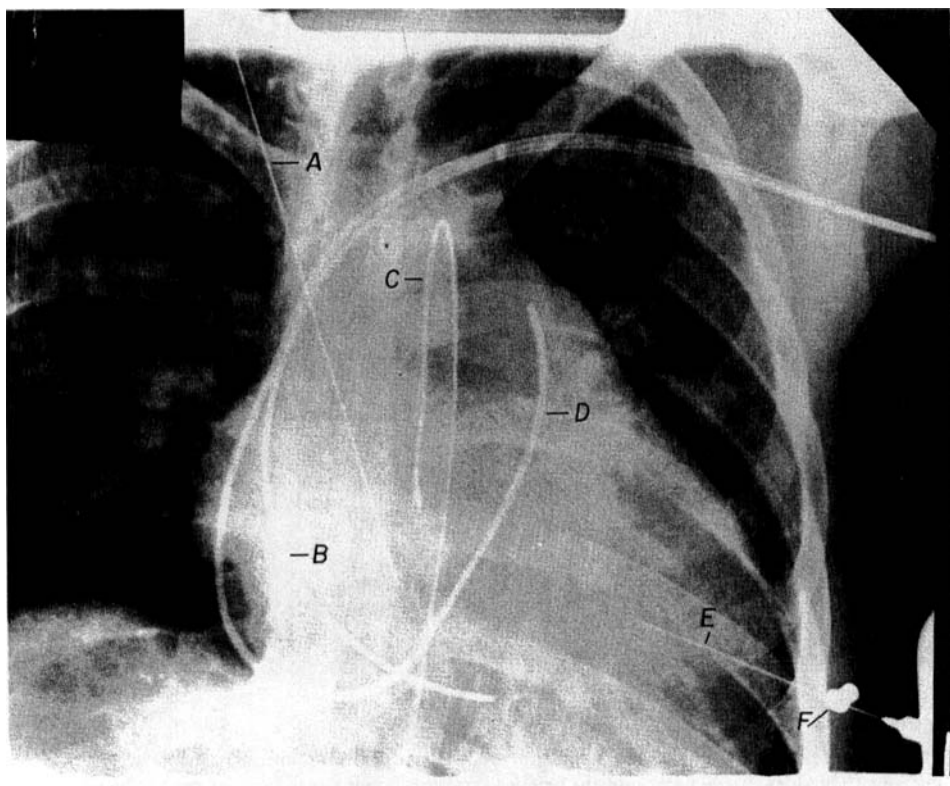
Roentgenogram of the thorax of a 40-year-old man demonstrating the positions of needles and catheters during combined puncture of the left atrium and the left ventricle and catheterization of the aorta and the right side of the heart. (A) 21T-gauge needle, 23 cm long, outside diameter 0.8 mm, internal diameter 0.6 mm, has been inserted via the suprasternal route, and its tip has been advanced until it lies in the left atrium, (B) no. 6-F cardiac catheter, introduced by percutaneous needle puncture of a vein in the left arm, has been advanced until its tip lies in the right ventricle, (C) no. 5-F aortic catheter, introduced by percutaneous needle puncture of the right femoral artery, has been advanced such that its tip lies above the aortic valve, (D) second catheter, No. 7-F, introduced similarly via a second vein in the same arm, has been advanced such that its tip is positioned in the pulmonary artery, (E) 21T-gauge needle has been inserted into the left side of the thorax at the position of maximal cardiac impulse, and its tip has been advanced until it has entered the left ventricular cavity, and (F) the needle stop maintains the position of the needle in relation to the skin surface. (Reproduced from Wood, E. H., et al., *Mayo Clin. Proc.*, 33, 581, 1958. With permission.)
